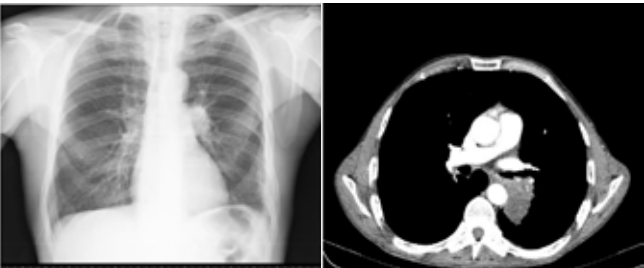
PA chest radiography demonstrating left hilar enlargement and thoracic CT images demonstrating left hilar mass (a,b).
